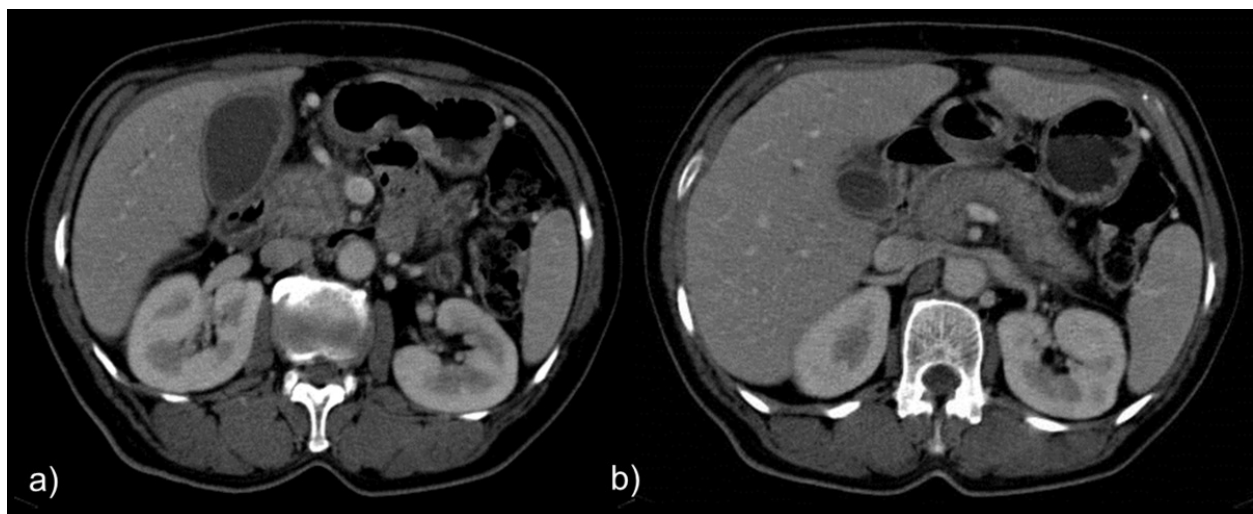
Enhanced axial CT images in portal venous phase of a patient with slight diffuse enlargement of pancreas, with diffuse less enhancement and loss of normal fatty lobulation. A slight atrophy of the pancreatic tail can be seen as well as a low-attenuation halo surrounding pancreas.
